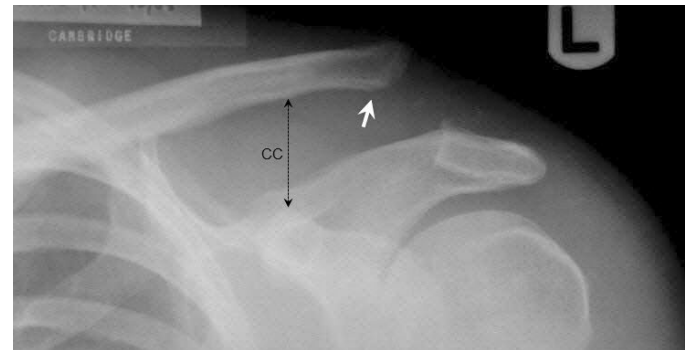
Initial anteroposterior radiograph reveals superior elevation of the left clavicle (arrow) and marked widening of both the AC joint space (22 mm) and CC (coracoclavicular) space (32 mm).
